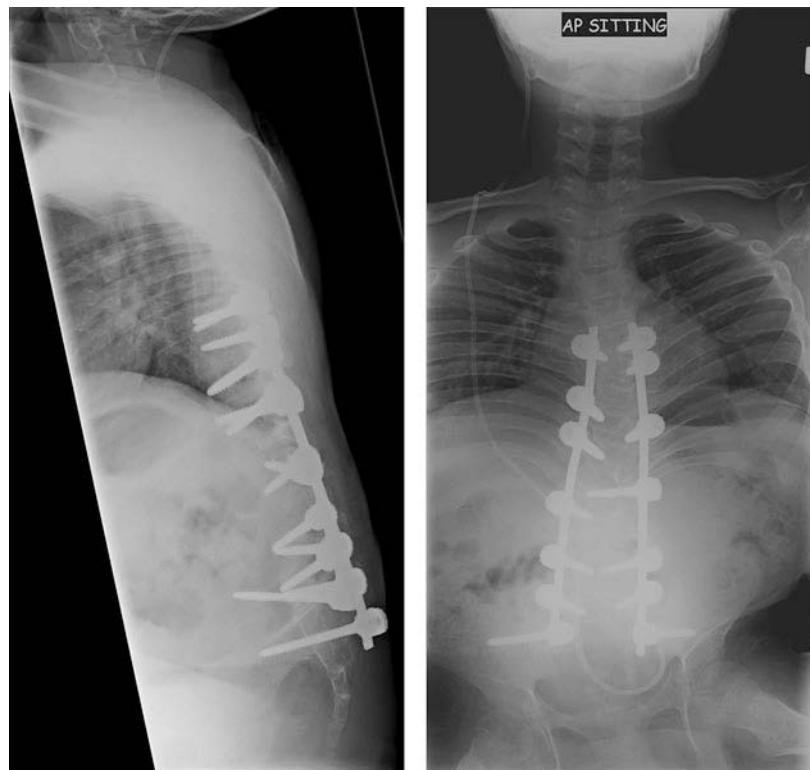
Postoperative x-ray confirming pedicle screw-based construct correction.
